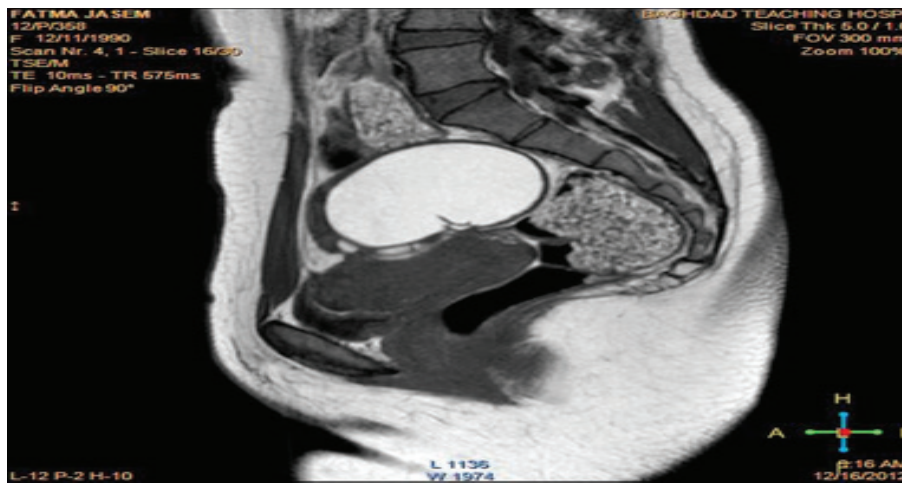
T2 weighted imagesagittal MRI views high signal intensity.
